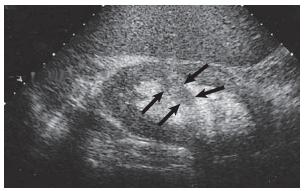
Sagittal renal ultrasound image. Column of Bertin is present (arrows) and is easily identified because of echotexture similar to that of renal cortex.
